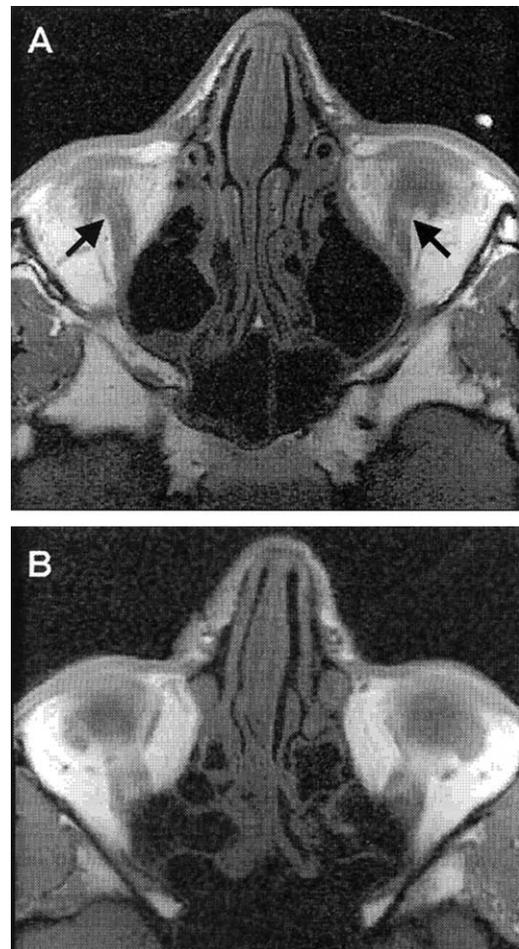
A, High-resolution magnetic resonance imaging scan showing angle deformities in the IR muscles (black arrows) in patient 19 after enhanced ANT procedure. The IO muscle was inserted 4 mm nasal to the IR muscle insertion. B, A comparable image from a normal subject. IR, inferior rectus; ANT, anterior and nasal transposition; IO, inferior oblique.
